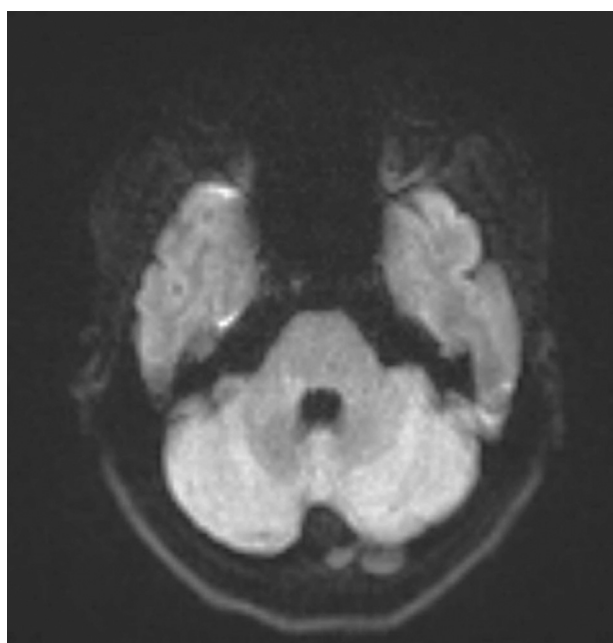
Brain MRI DWI sequence. No evidence of diffusion restriction.
